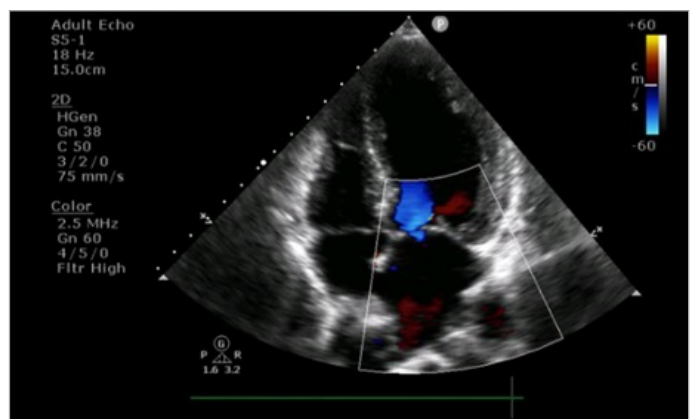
Complementary Diagnosis Exams - echocardiogram. Transthoracic echocardiogram revealing anterolateral and apical mediobasal hypokinesia. Mild depression of left ventricular systolic function, with an ejection fraction of 41%.
